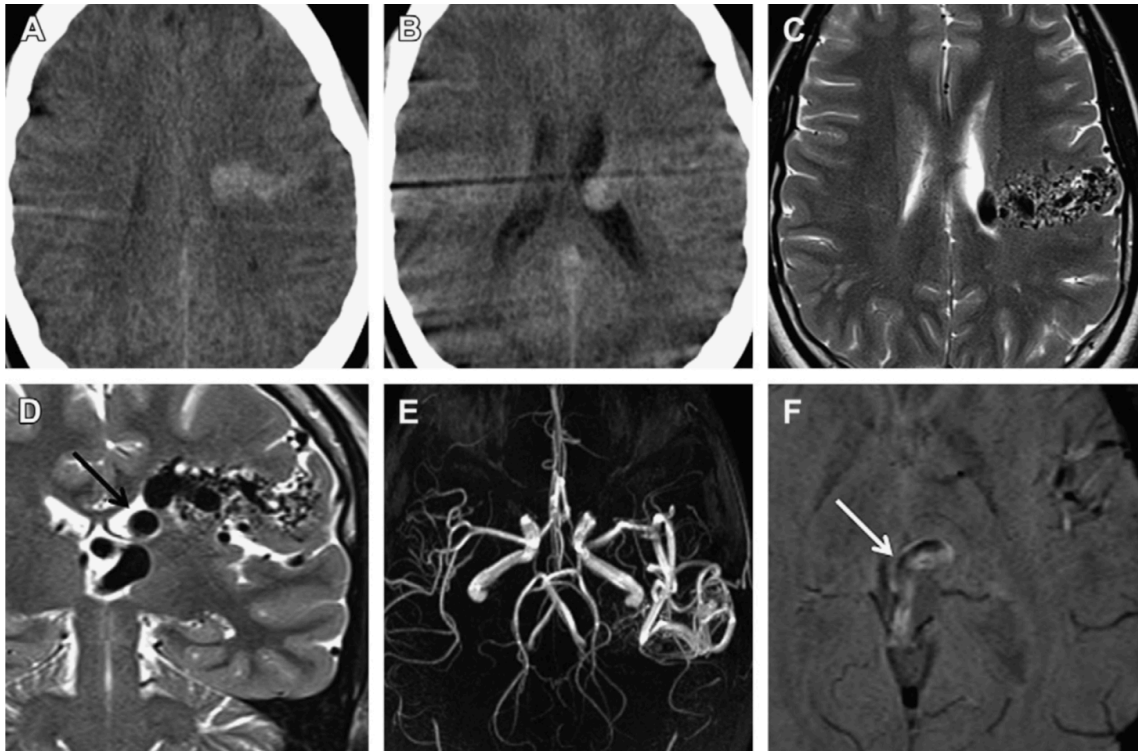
A 16-year-old female patient who initially presented to the emergency department after tonic-clonic seizures. Axial noncontrast CT images (A and B) show a hyperattenuating serpentine vascular structure coursing from the left corona radiata into the left lateral ventricle. On axial (C) and coronal (D) T2-weighted sequences, there is a prominent plexiform transmantle perirolandic arteriovenous malformation with a prominent draining terminal vein (arrow), which empties deeply into the left basal vein of Rosenthal. Perinidal T2 hyperintensity relates to gliosis. Noncontrast enhanced 3-dimensional time-of-flight magnetic resonance angiography (3D TOF MRA) 3D reformat image in axial plane (E) again shows AVM nidus being supplied by multiple distal left middle cerebral artery (MCA) branches. Draining venous structures are not well depicted. Axial susceptibility-weighted image (F) shows hyperintense signal within prominent left basal vein of Rosenthal (arrow) relating to high-flow arteriovenous shunting.
